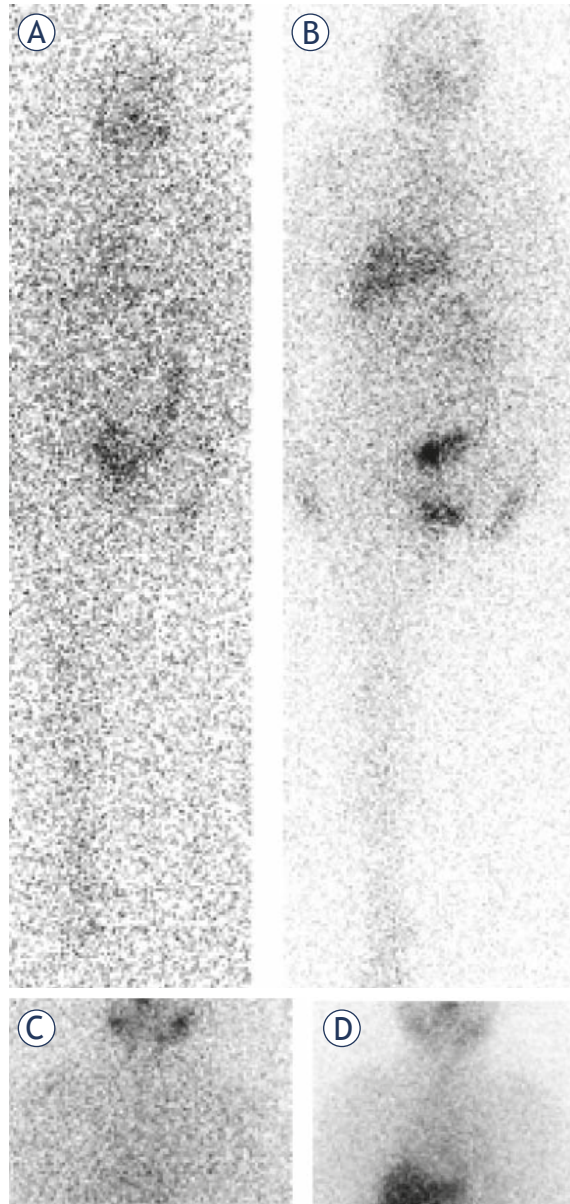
Radiiodine scans in the patient who underwent therapy with 7400 MBq (200 mCi) of ^{131}I . This patient had small pulmonary nodules seen on computed tomography images performed 7 months before LID. A diffuse radiiodine uptake is seen in liver. Focal accumulation of ^{131}I was not visible. Prior to LID, this patient had urinary iodine concentration of 169.6 $\mu\text{g/L}$, and post-LID value was 89.0 $\mu\text{g/L}$. Anterior whole body scans (A) prior to LID and (B) post LID; static scans of the neck and the thorax region (C) prior to LID and (D) post LID.
